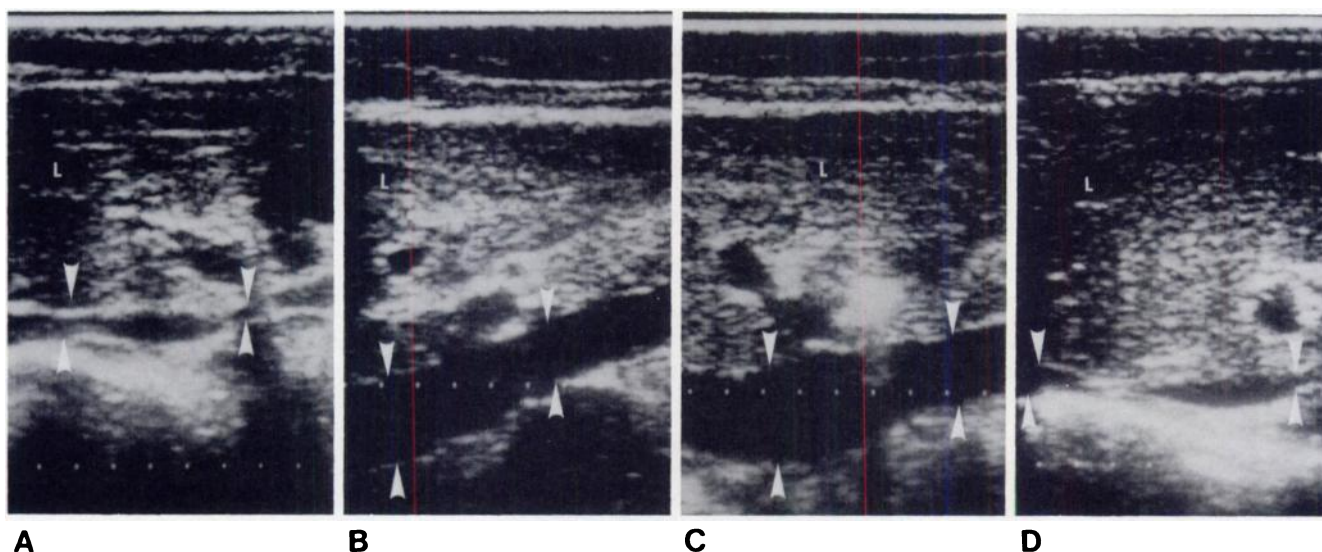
One patient. A, Longitudinal sonogram during inspiration. Inferior vena cava (arrowheads). L = liver. B, Longitudinal sonogram at end expiration. Distended inferior vena cava (arrowheads). C, Longitudinal sonogram with breath held after deep inspiration. Vena cava (arrowheads) in most
